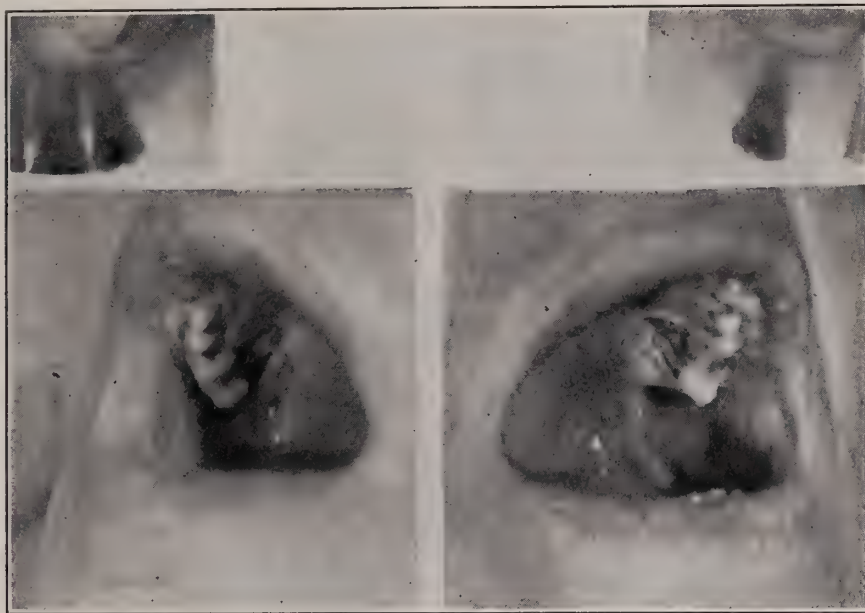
Photograph of maxillary molar teeth showing extensive bone destruction about the palatal roots. Radiograph fails to show this destruction of bone.
